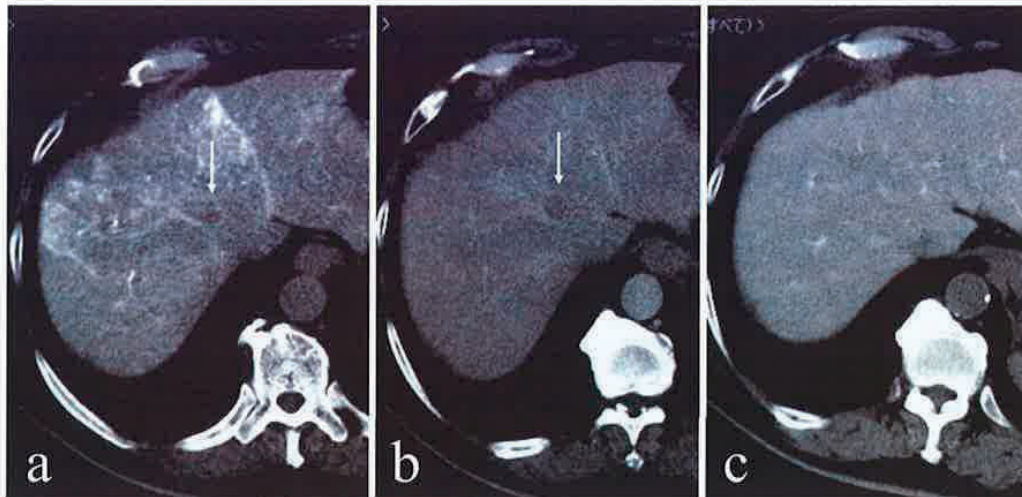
Imaging findings of CT arteriportal angiography. CTHA reveals a hypovascular nodule in both (a) the early phase (arrow) and (b) the late phase (arrow), (c) although CTAP does not reveal any perfusion defect. CTHA was performed using 40-60 mL of contrast medium at the rate of 2-3 mL/s into the common hepatic artery, scanned early phase (15 s) and late phase (60 s). CTAP was performed using 80-90 mL of contrast medium at the rate of 2-3 mL/s.
